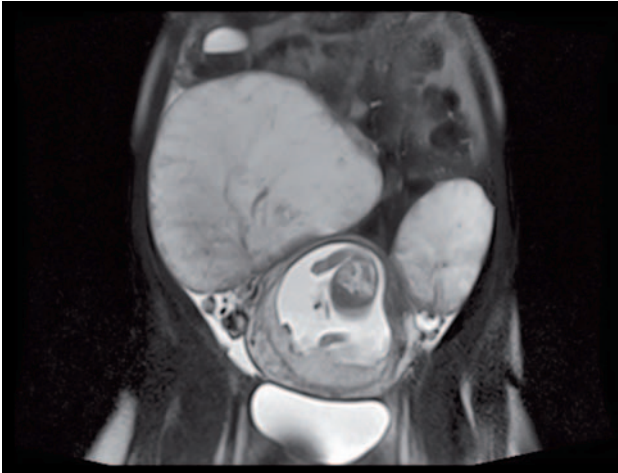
Coronal T2-weighted image shows a gravid uterus and homogenous hyperintense solid mass lesion at both iliac fossae, with the right mass being greater than the left one.
